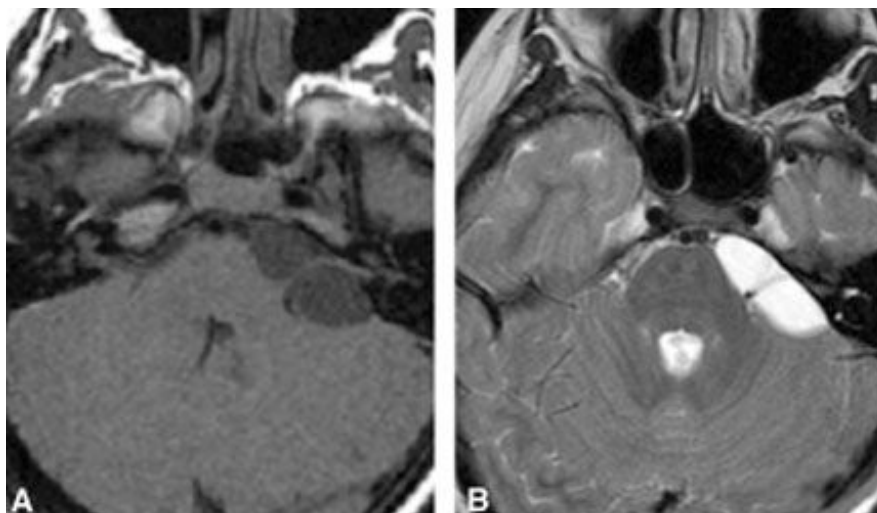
(A) T1- and (B) T2-weighted images of a cerebellopontine angle arachnoid cyst. The cyst matches the signal of cerebrospinal fluid on all sequences and is not enhance. Note the mass effect and distortion of the left vestibulocochlear nerve complex
